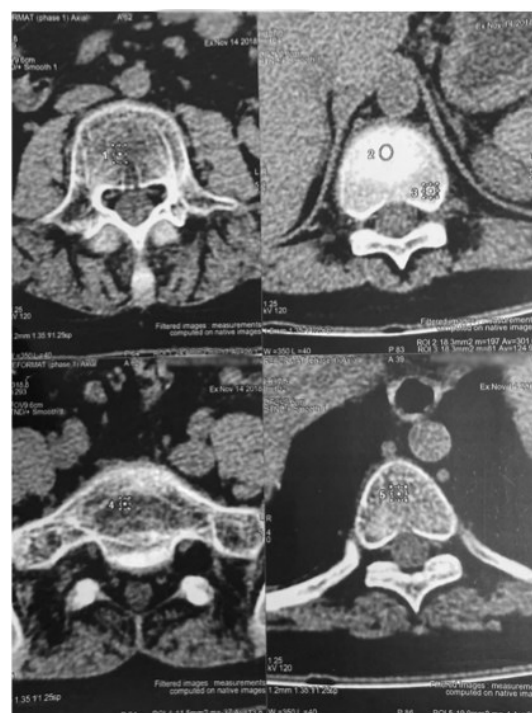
CT-scan of spine, measuring the *Hounsfield unit* (HU)
